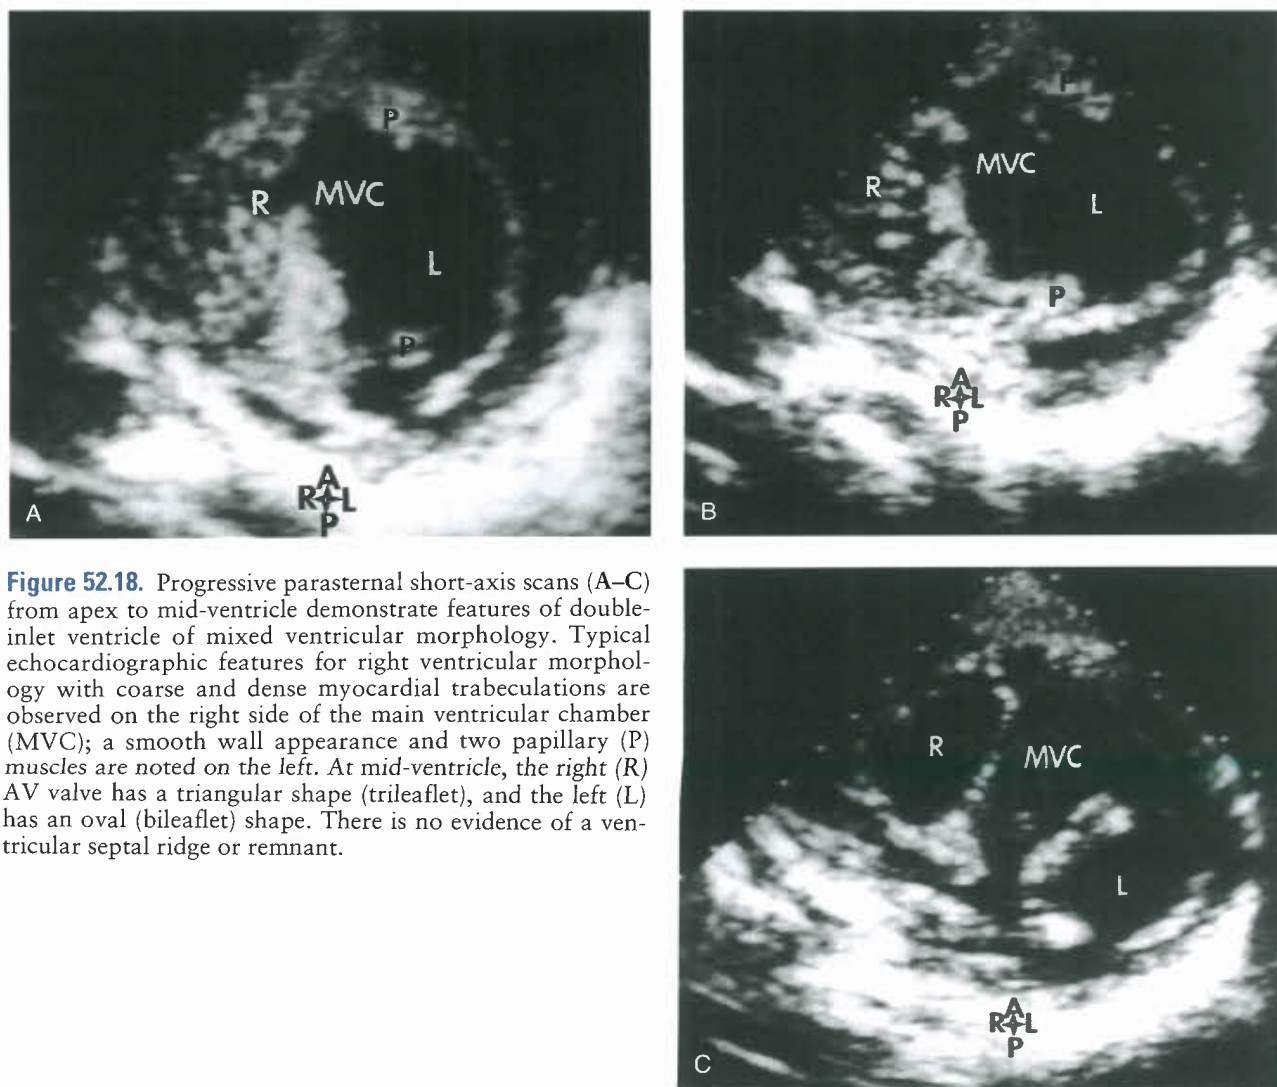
Progressive parasternal short-axis scans (A–C) from apex to mid-ventricle demonstrate features of double-inlet ventricle of mixed ventricular morphology. Typical echocardiographic features for right ventricular morphology with coarse and dense myocardial trabeculations are observed on the right side of the main ventricular chamber (MVC); a smooth wall appearance and two papillary (P) muscles are noted on the left. At mid-ventricle, the right (R) AV valve has a triangular shape (trileaflet), and the left (L) has an oval (bileaflet) shape. There is no evidence of a ventricular septal ridge or remnant.
